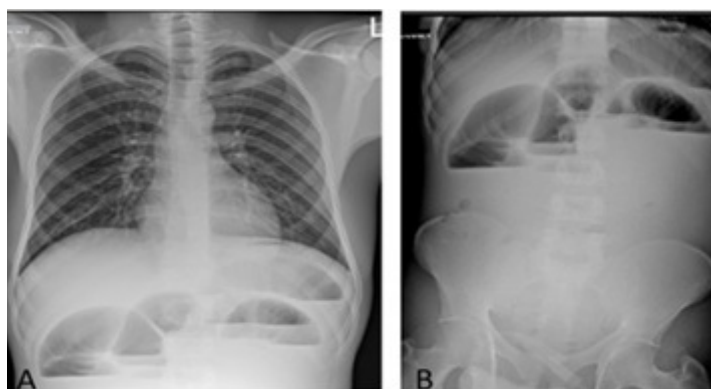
Preoperative chest x-ray and erect abdominal x-ray
